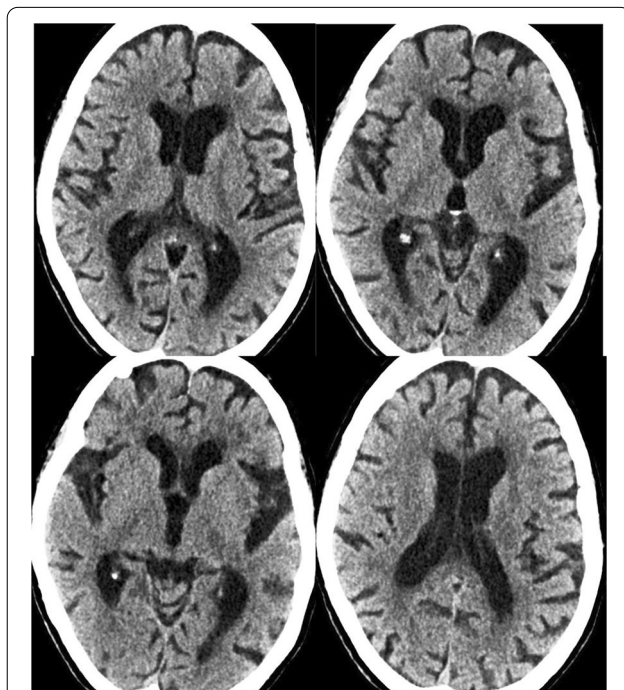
First CT Findings (done within 2 h from complaint starting): showing age related brain involutional changes with arteriosclerotic leukoencephalopathy and bilateral ganglionic tiny old lacunar infarcts. No fresh blood density or evidence of acute vascular insult
